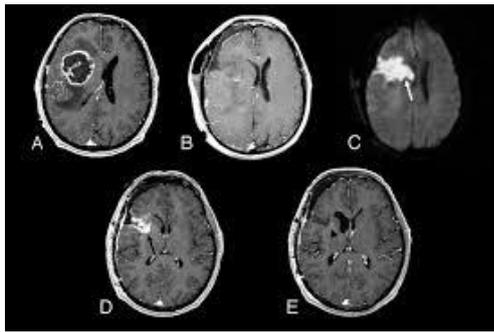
Brain MRI outputs
